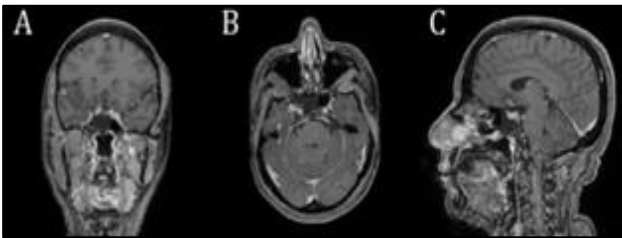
MRI of brain (A) Coronal view (B) Axial view (C) Sagittal view showing: Focal bony defect at the posterior wall of the right sphenoid sinus with erosion and small cyst-like structure at the cranial aspect of the wall and intra sinus calcification at the site of the defect.
